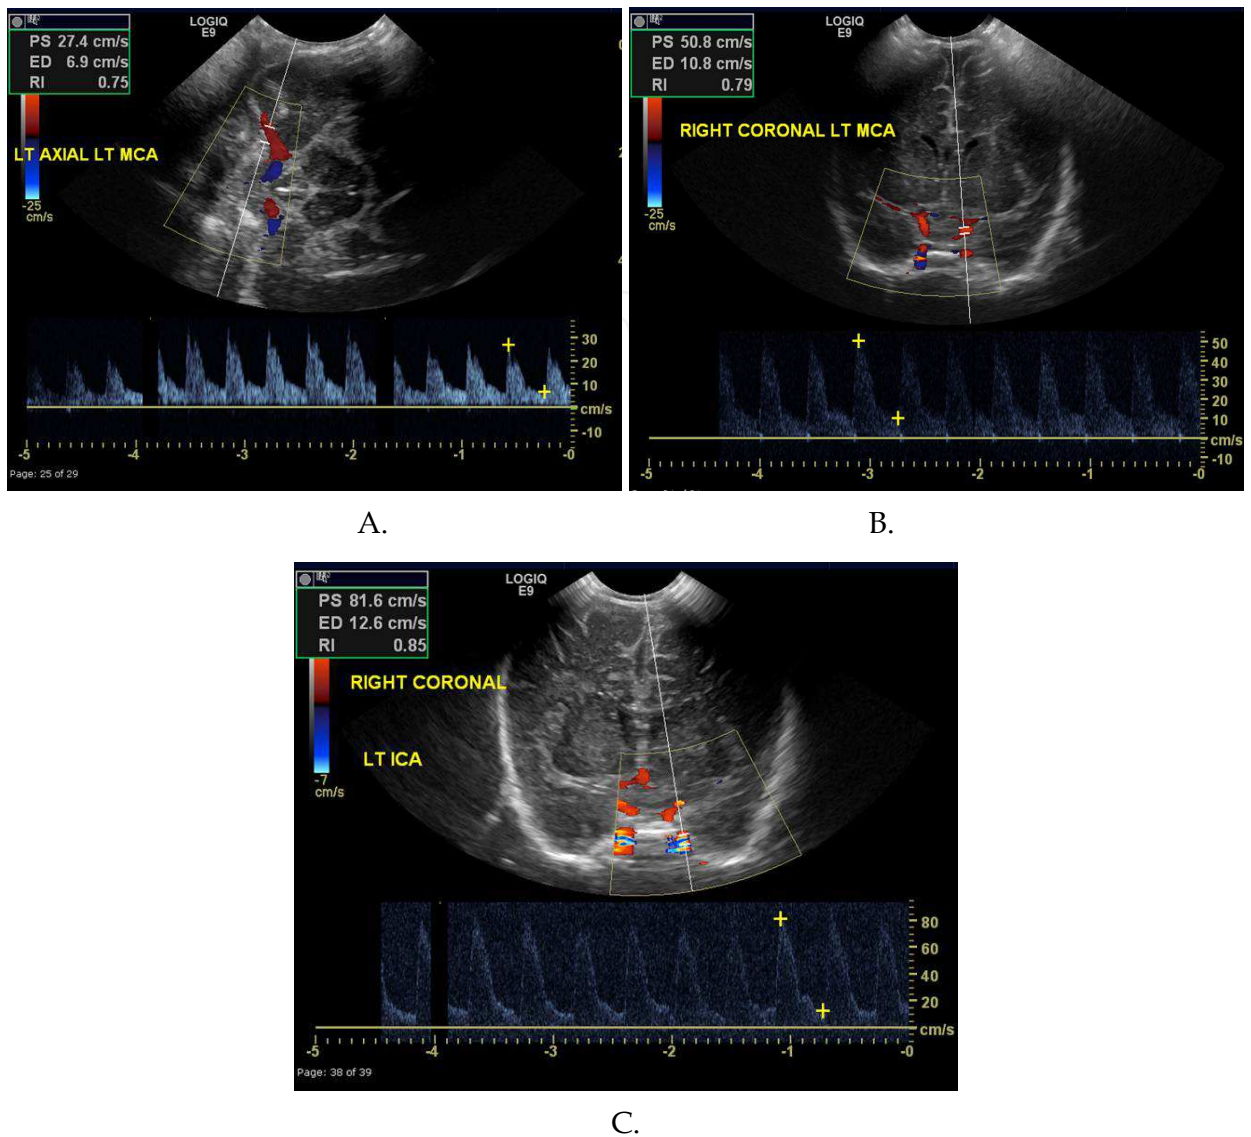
(a) Axial and (b) coronal Doppler images and spectral waveforms of the normal Circle of Willis. Axial images were obtained through the temporal fontanel. Coronal images were obtained through the anterior fontanel. (c) Coronal Doppler images and spectral waveforms of a normal ICA obtained through the anterior fontanel.
